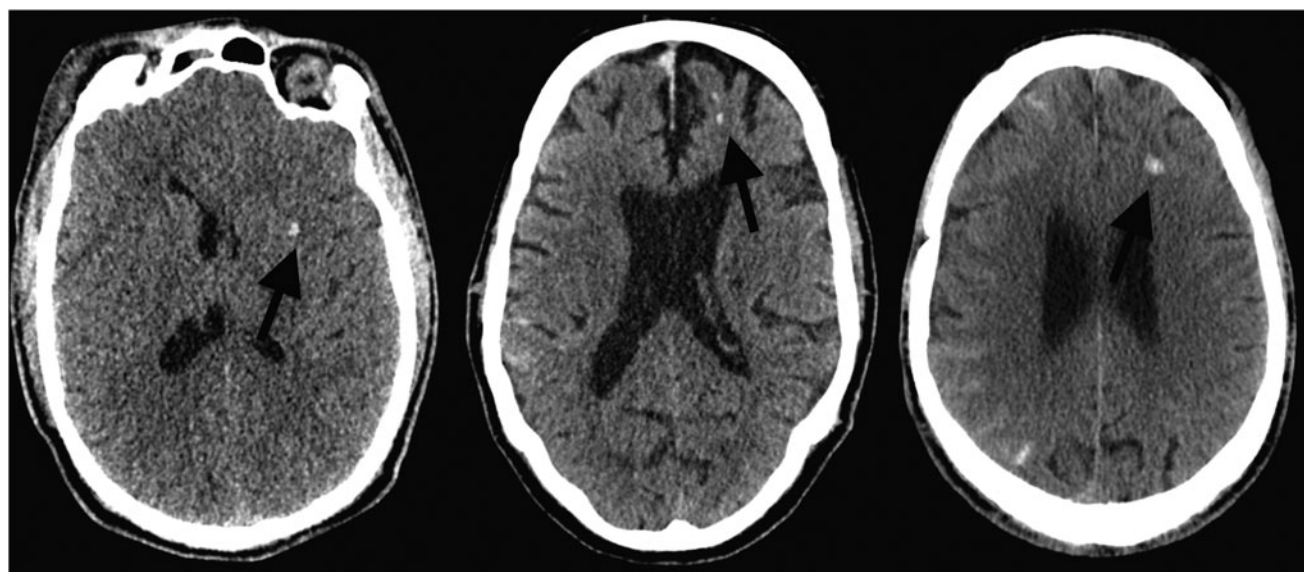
Examples of discordances in three different patients between the central review and the centers for traumatic axonal injury (TAI). The small focal hyperdense lesions indicated by the arrows were all classified as TAI by the central review, as opposed to contusion by the centers. Lesions occurring at the gray–white matter junction are specifically difficult to discriminate on computed tomography imaging.
